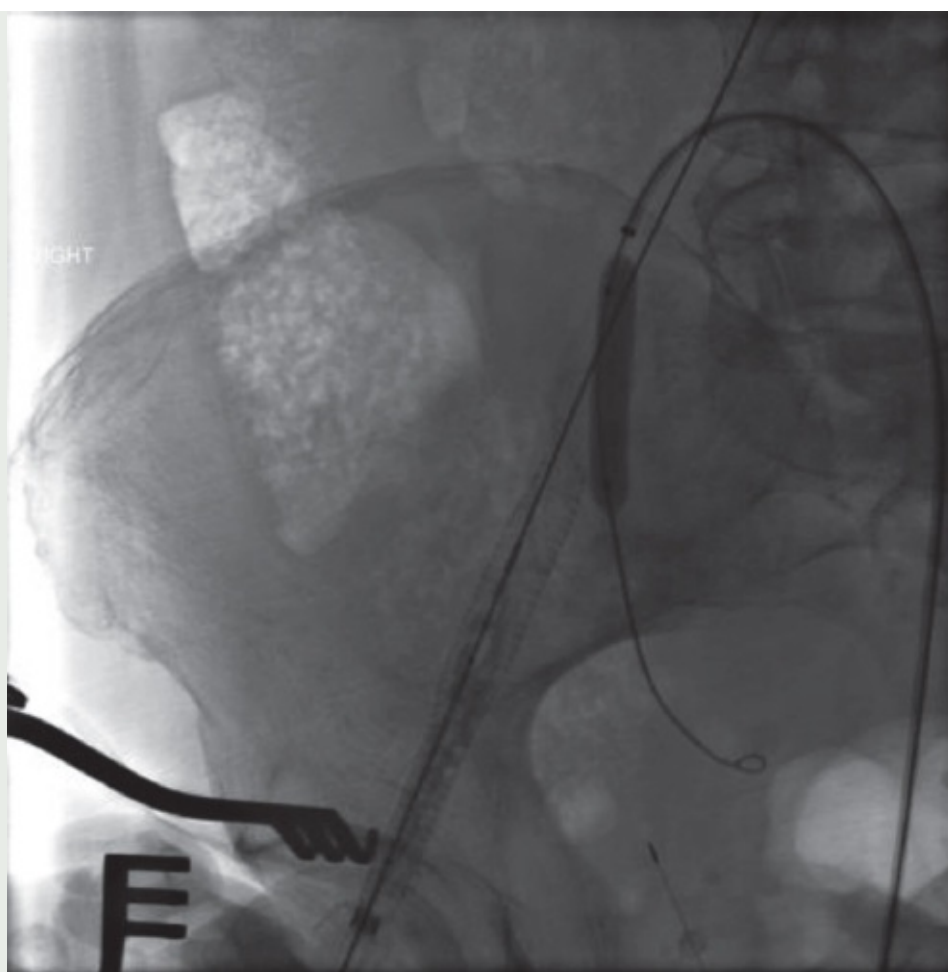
A and B, On the CT scan of the access vessels, both femoral arteries and external iliac arteries were 5 to 6 mm. Therefore, planned controlled prerupture of the right iliac artery was discussed. This has been shown to be a useful adjunct in selected cases of difficult iliofemoral access and can be done to avoid the morbidity of construction of a retroperitoneal iliac artery conduit.<sup>5</sup>
